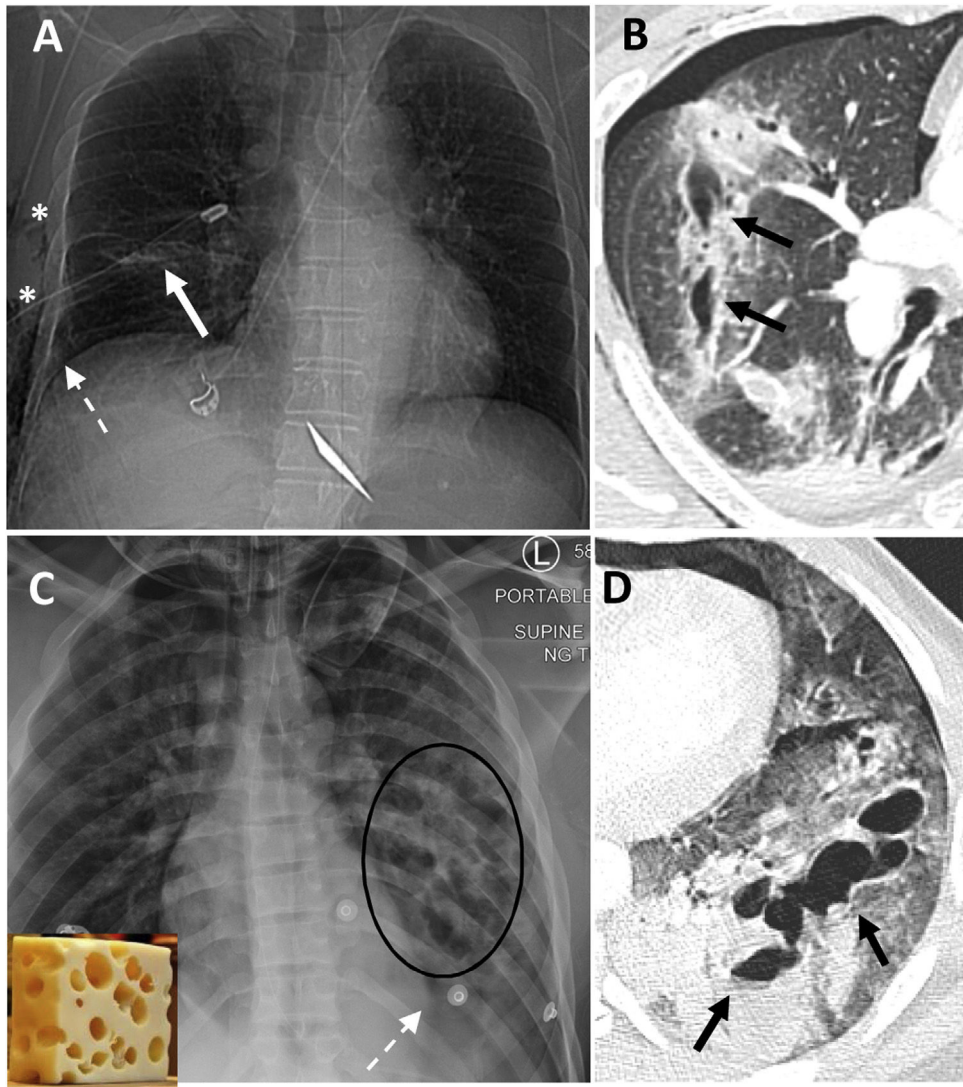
Images of two patients with penetrating thoracic trauma caused by stabbing (top row) and blunt trauma (bottom row). A) Chest CT topogram showing linear opacity in the right lung (arrow), subcutaneous emphysema (asterisks) and pneumothorax (dashed arrow). B) Axial chest CT image (lung window) showing a single lung laceration with linear morphology (arrows). C) Portable radiograph showing poorly defined opacity in the left lung (ellipse) and pneumothorax (dashed arrow). D) Axial chest CT image (lung window) showing multiple lung lacerations with round/oval morphology (arrows) resembling 'Swiss cheese'. These patients often have pulmonary contusions surrounding the lacerations and small ipsilateral pneumothoraces.
